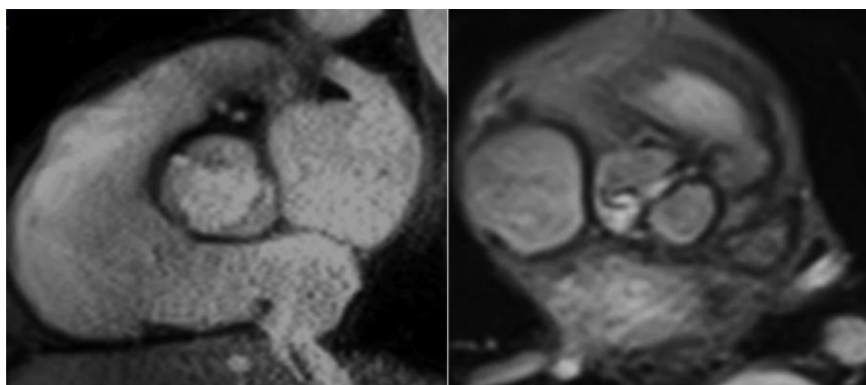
An example of a normal (left) and a stenosed (right) tri-leaflet aortic valve on Magnetic Resonance Imaging
